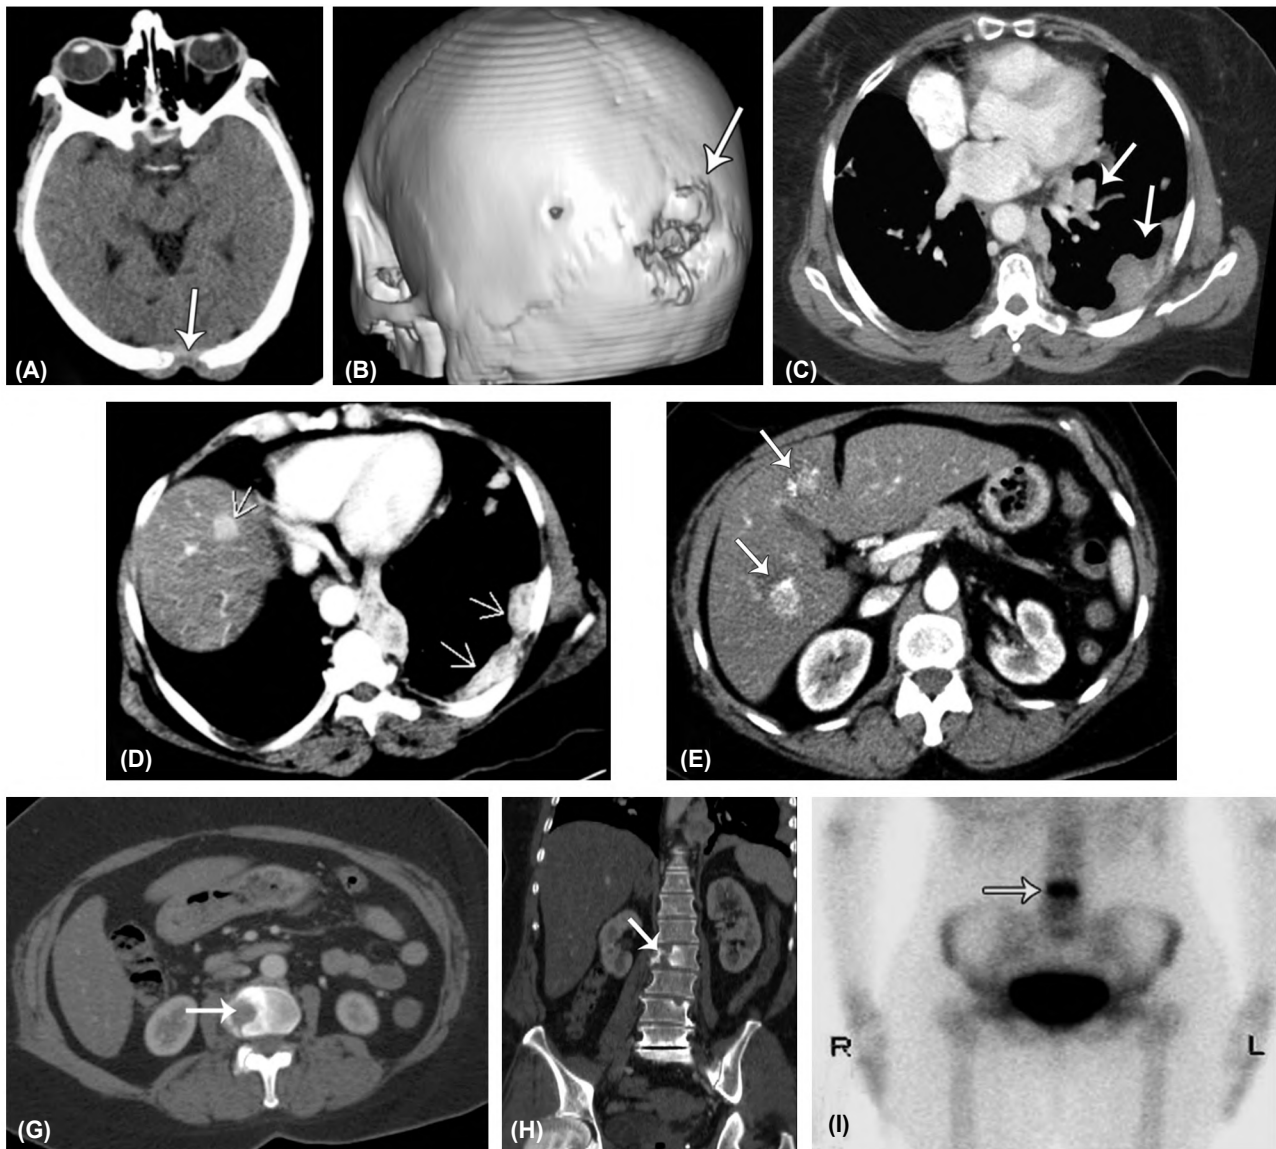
(A,B): CT skull (A) axial and (B) volumetric VR -3D reformatting showing multiple osteolytic lesions of the skull bones associated with soft tissue component in the occipital and left parietal bones. (C,D,E): Axial post contrast CT chest and abdomen showing multiple variable sized pulmonary and plural soft tissue masses in both lung lobe (more in the left side) with few right liver lobe enhancing focal lesions. (G,H): Axial and coronal post contrast CT abdomen and pelvis showing osteolytic destructive lesions of L2 & L4 vertebrae. (I): Increased tracer uptake at L4 vertebra metastatic lesion.
